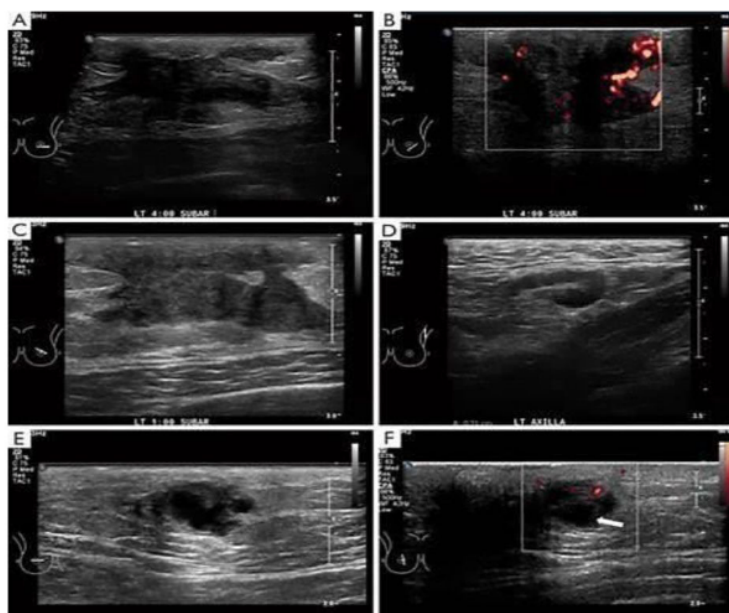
Ultrasound image showing ill-defined hypoechoic lesion with surrounding edema.
